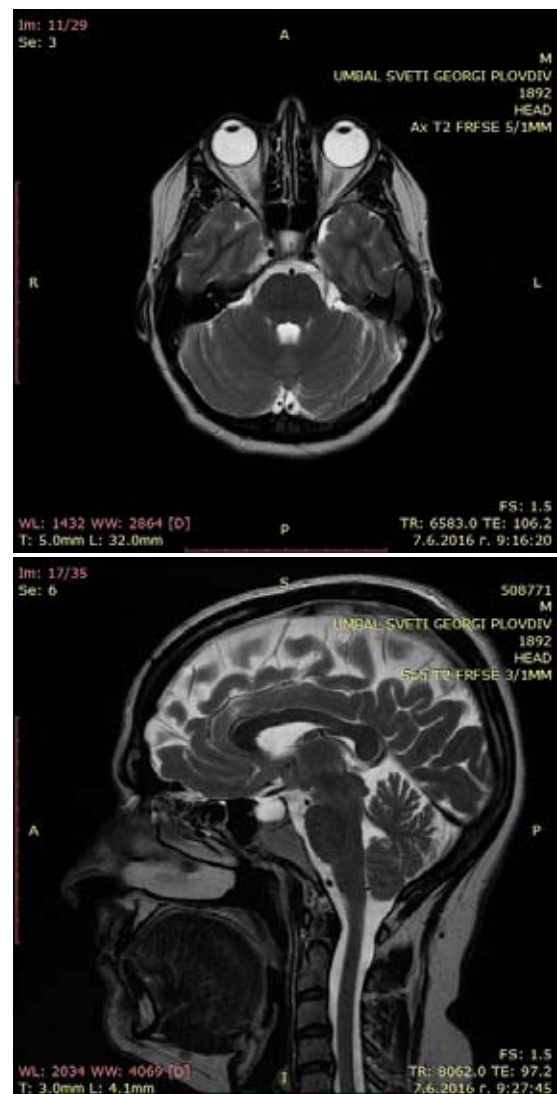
T2 weighted MRI imaging in sagittal and axial projections.
